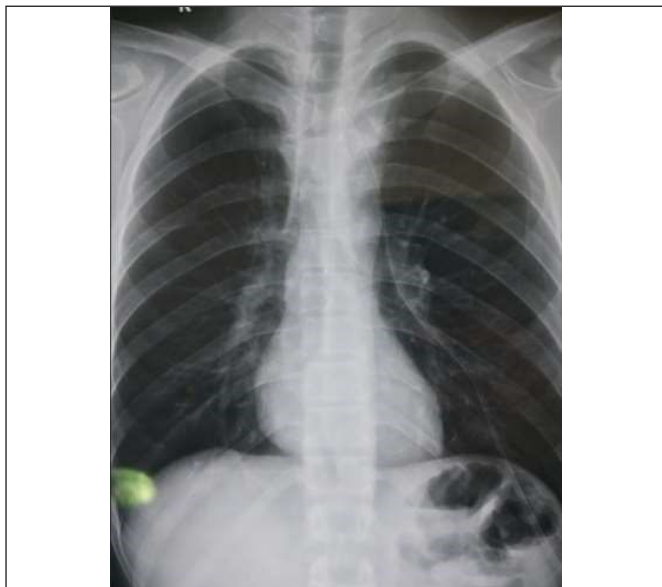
Chest X-Ray after removing International Classification of Diseases (ICD).
